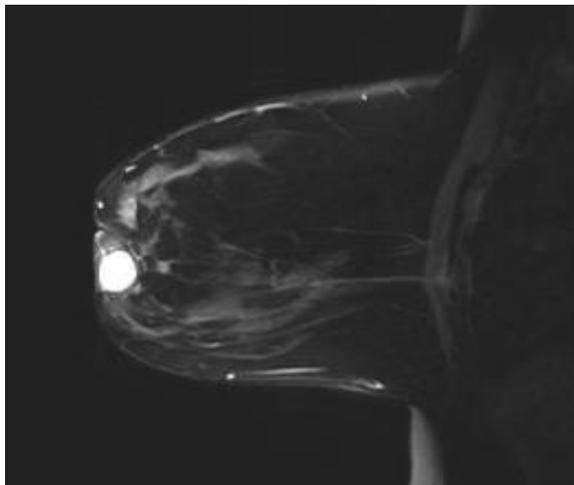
Right breast MRI showing retroareolar (looking to be intraductal) circumscribed oval shaped mass lesion measuring about 25 x 20 mm, displaying rim enhancement.
